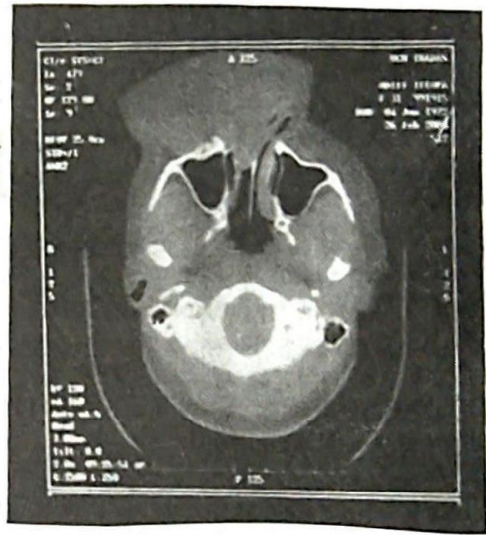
CT scan of the sinuses and brain (axial view)
